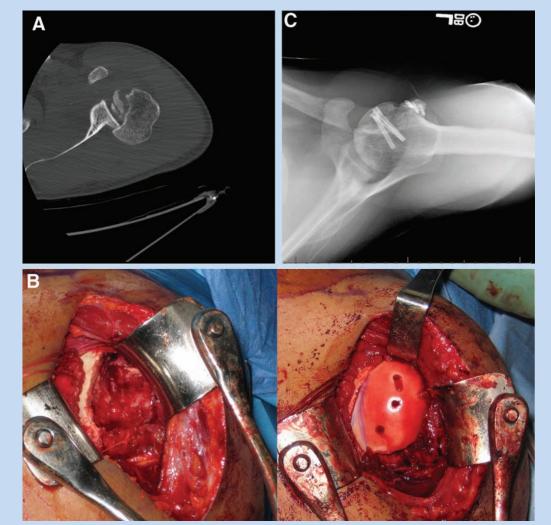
Osteochondral allograft reconstruction of large reverse Hill-Sachs defect in a patient with a chronic locked posterior dislocation following a seizure. A, computed tomography scan of a chronic locked posterior dislocation in a patient following a seizure. B, large reverse Hill-Sachs defect exposed during surgical approach before and after osteochondral allograft reconstruction. C, 10-month follow-up showing healing and integration of the allograft.
